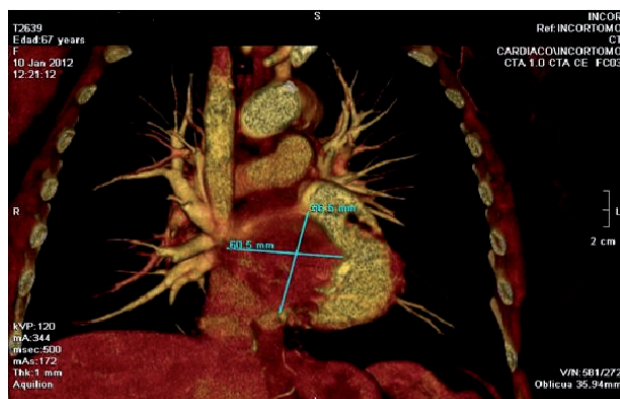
Multislice helical computed tomography reconstruction showing solid tumor of 60 × 58 × 40 mm in the inferior aspect of the anterior wall of the left atrium.
